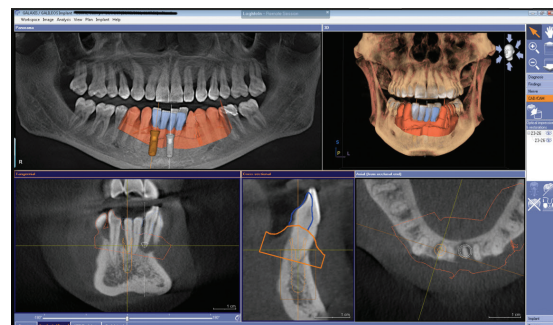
CBCT scan with a Cerec Bluecam overlay showing ideal final result
